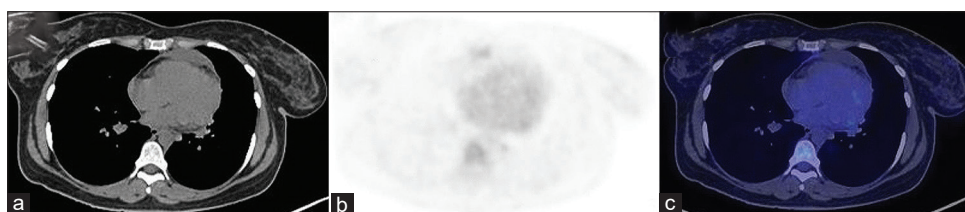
CT image in mediastinal window (a), MIP PET image (b), and axial fused image (c) of follow up imaging made after 5 days interval revealed no such hypermetabolic focus in the same site which proves again to be a temporary hot clot.
